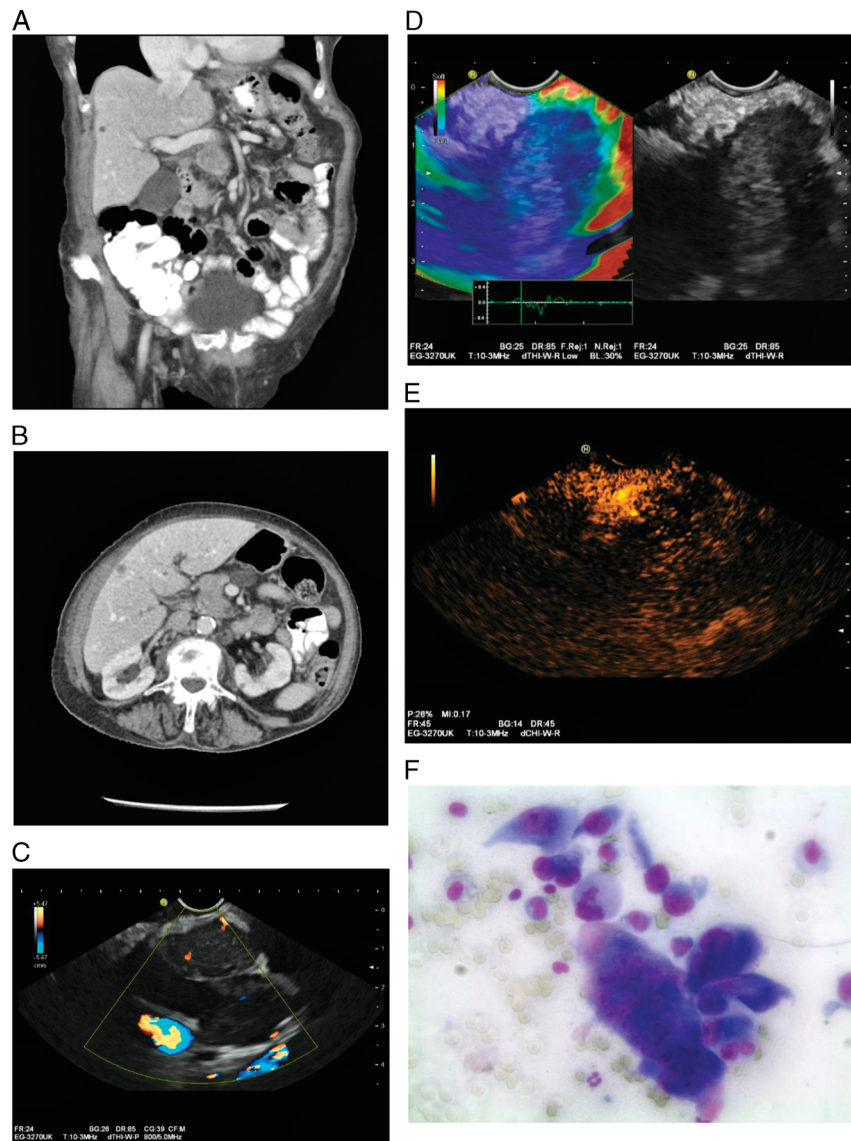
Osteoclast-like adenocarcinoma of the pancreas. Tumor in the pancreatic head on CT on sagittal reconstruction (A) and transversal reconstruction (B). On EUS, the tumor appears well-delineated and in 2 parts (what is down to the scanner's position and not to the tumor itself). The tubular structure coming from the lower bit of the tumor is the massively enlarged pancreatic duct (C). The elastographic image of the tumor has a blue color coding—so the tissue is harder than the tissue in the environment (D). In CH-EUS (Contrast-Harmonic EUS), the tumor is hypoenhanced (E). Hypoenhancement is a typical feature of PDACs. Cytology resulting from an endosonographic FNA (F): the osteoclast-like tumor cell is displayed in the middle and very distinctive because of the multiple cell cores within the massively enlarged cell (PD Dr Hocke, Meiningen). Image source of CT angiogram: Dr H.-J. Hald, Helios Hospital Meiningen, Radiology.
